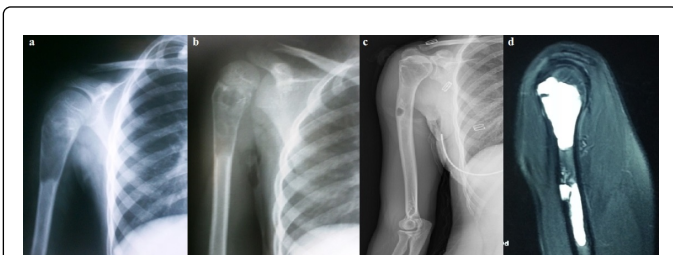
An 8-year-old female patient. Active bone cyst in proximal humerus, a. Steroid therapy was applied; b. Control image from 3rd month; pathological fracture developed; c. Control image in the 3rd year; and it was accepted as being at residual recovery phase; d. The inside of the cyst is filled with fluid as found in MRI imaging is seen.
